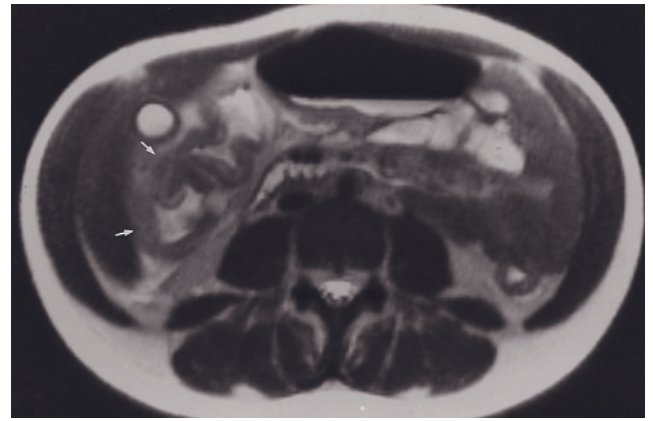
Neutropenic colitis (typhlitis). Coronal T2-weighted SS-ETSE (a) and coronal interstitial-phase gadolinium-enhanced SGE (b) images in a patient with acute myelogenous leukemia history. There is marked thickening of the ascending colon (arrows, a, b) consistent with neutropenic colitis. Small bowel thickening and ascites are also present. Coronal (c) and transverse (d) T2-weighted SS-ETSE and transverse interstitial-phase gadolinium-enhanced SGE (e) images in a second patient after chemotherapy. The cecum shows dilatation with marked thickening and enhancement of the wall (arrows, c, e).
